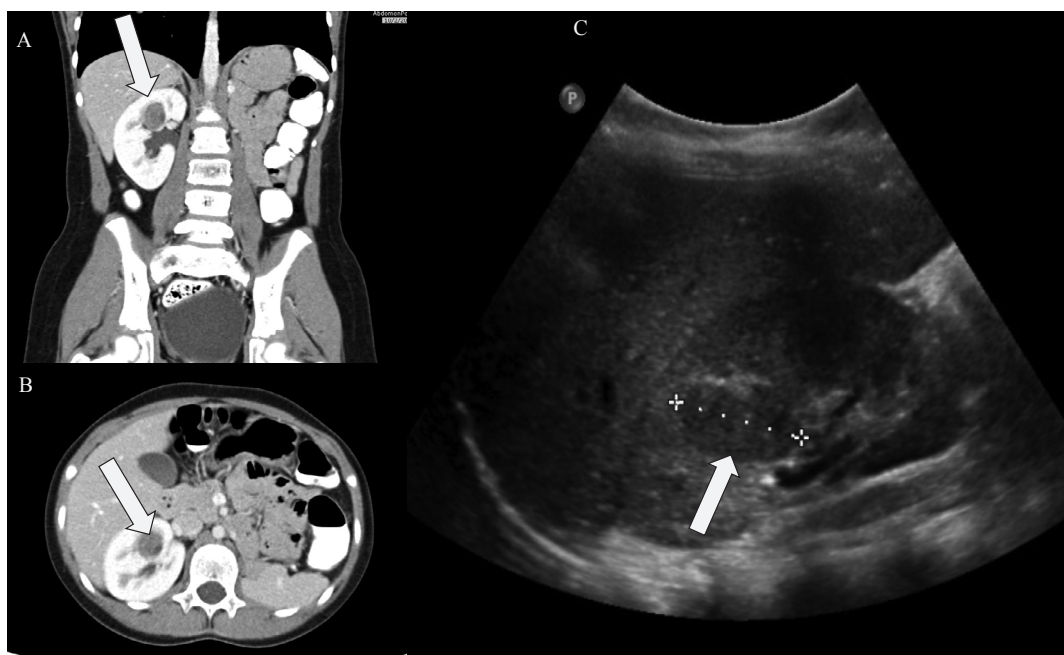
Concerning right upper pole mass (yellow arrows) on CT scan (a and b) and ultrasound (c).
